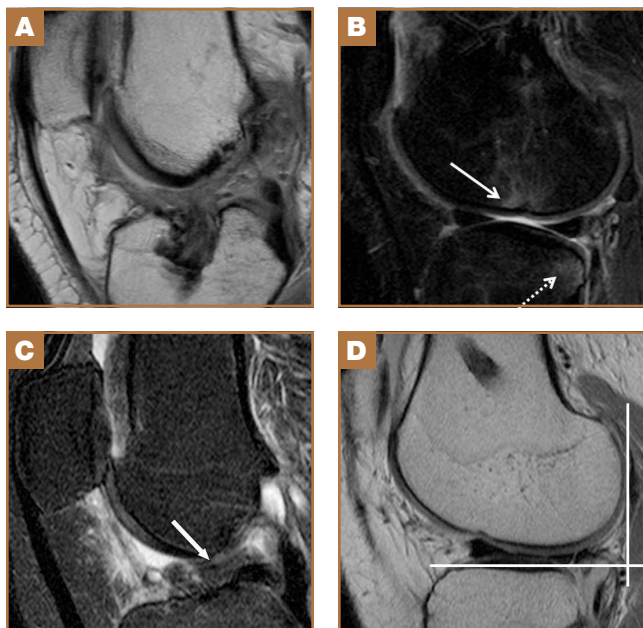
(A) Sagittal intermediate-weighted magnetic resonance imaging (MRI) shows complete rupture of anterior cruciate ligament (ACL) graft with no discernible intact fibers remaining. (B) Corresponding sagittal fluid-sensitive MRI (same patient) shows anterior lateral femoral condylar impaction fracture (solid arrow) and posterior tibial plateau subchondral contusion (dotted arrow), consistent with recent pivot-shift injury. (C) Sagittal fluid-sensitive and (D) intermediate-weighted MRI shows chronic complete tear of ACL graft with distal stump (white arrow) horizontally oriented within intercondylar notch (in C). Note associated anterior tibial translation (in D).
